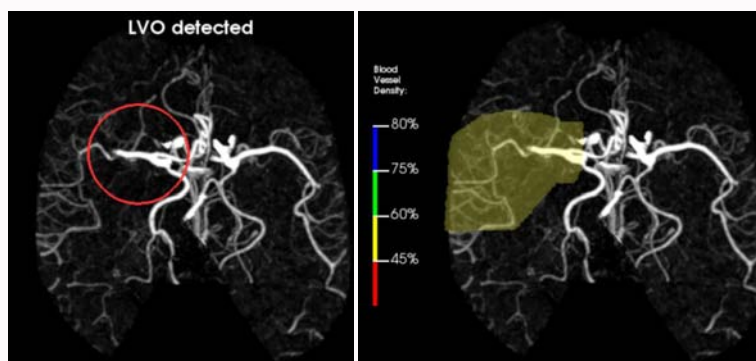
CT Angiogram: Showed a large vessel left M1/M2 occlusion.
